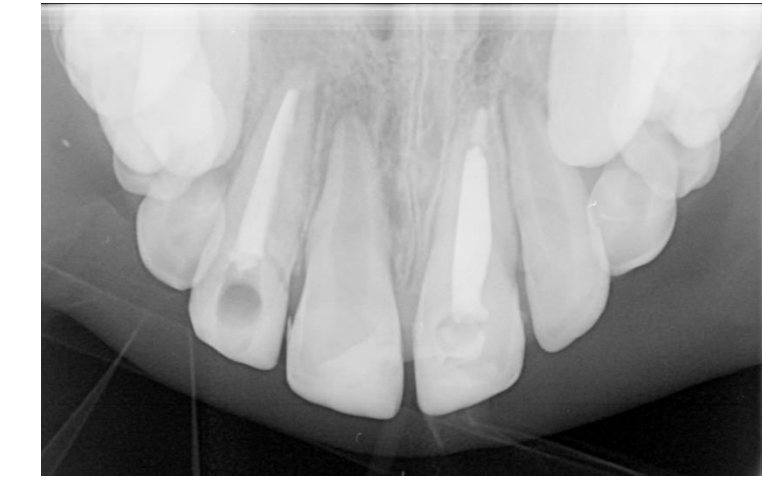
Occlusal view radiograph at one year, four months review
